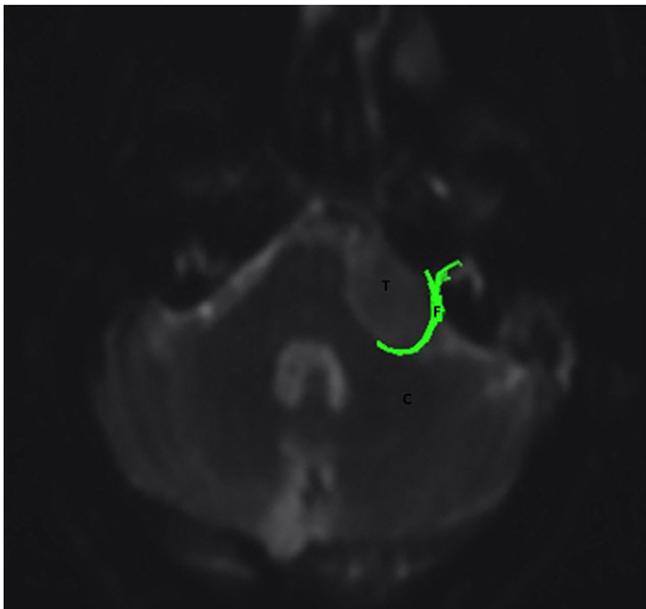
Axial T2-weighted MR image: DTT revealing the course of facial nerve, posterior to the tumor (green line). T: Tumor, C: Cerebellum, F: Facial.
